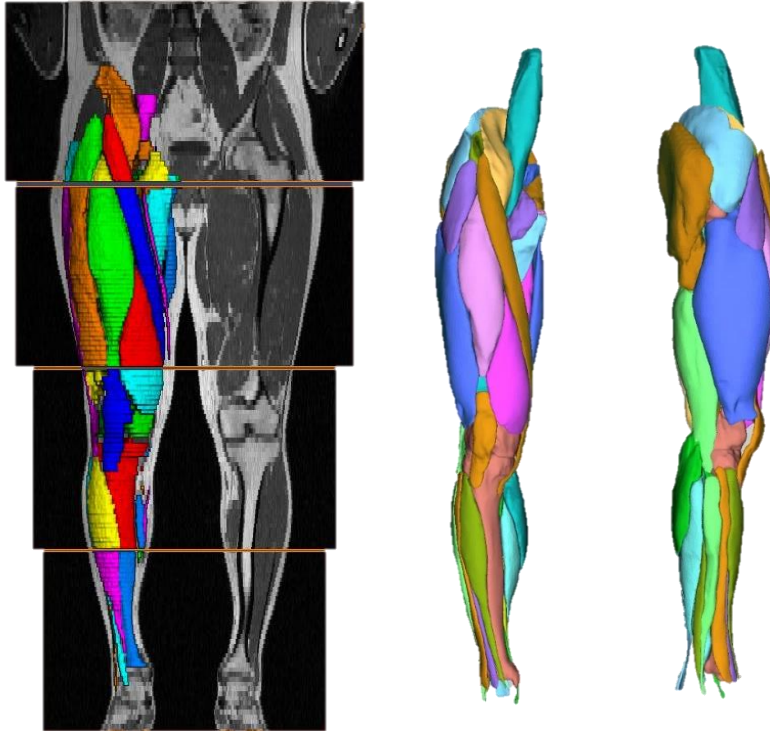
The segmented lower extremity muscles from MRI, the colors in the left-hand side image are chosen randomly and each muscle may be represented by multiple colors at different image levels. The final muscle surfaces are shown in the middle and right images from frontal and sagittal views.
